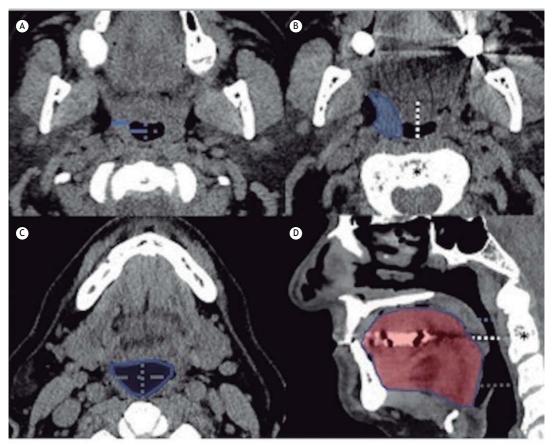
Representative axial and sagittal CT reconstructions of the pharynx during wakefulness in a patient with obstructive sleep apnea. Retropalatal region (A), at the level of the superior border of the C2 vertebral body (* in B), and retroglossal region (C). Contour of the lateral wall (blue outline in B) and lateral wall thickness (solid line in A); anteroposterior diameter of the pharynx (dotted lines in A, C, and D) and lateral diameter of the pharynx (dashed line in A and C); tongue-pharyngeal distance (white dotted line in D); retroglossal area (solid contour in C) and tongue delimitation (red area in D).
